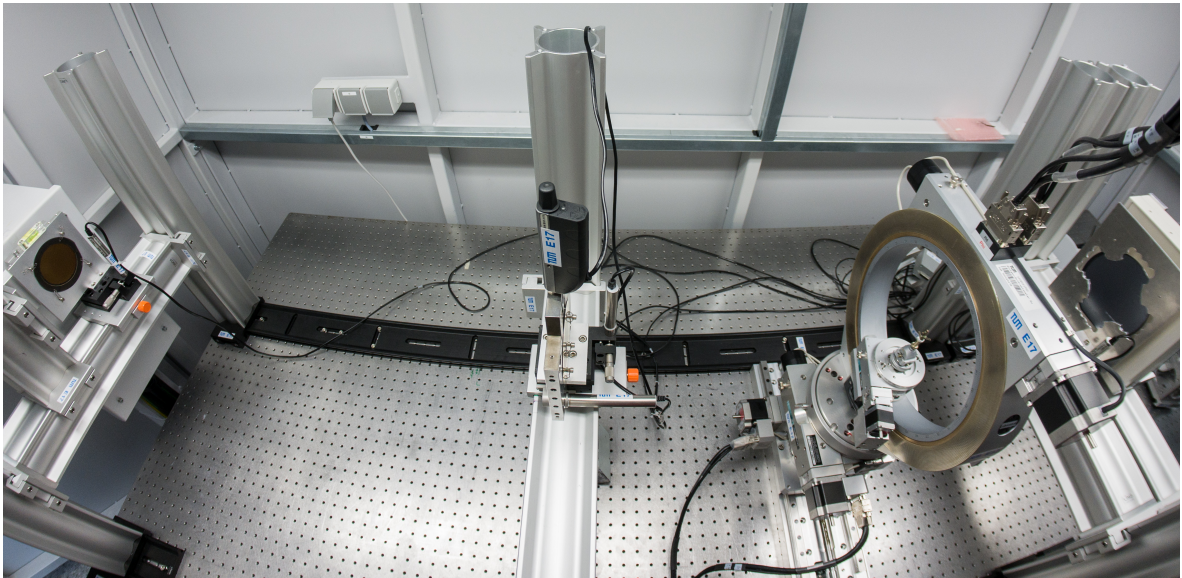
Wide-angle view of the actual setup. From left to right: X-ray source (T) with source grating (G_0) directly in front of it, at the center the phase grating (G_1), then a Eulerian cradle with sample (S), and adjacent to it the analyser grating (G_2 , in the cross-shaped holder); behind the latter the X-ray detector (D, hidden). (Courtesy of Christoph Jud.)
